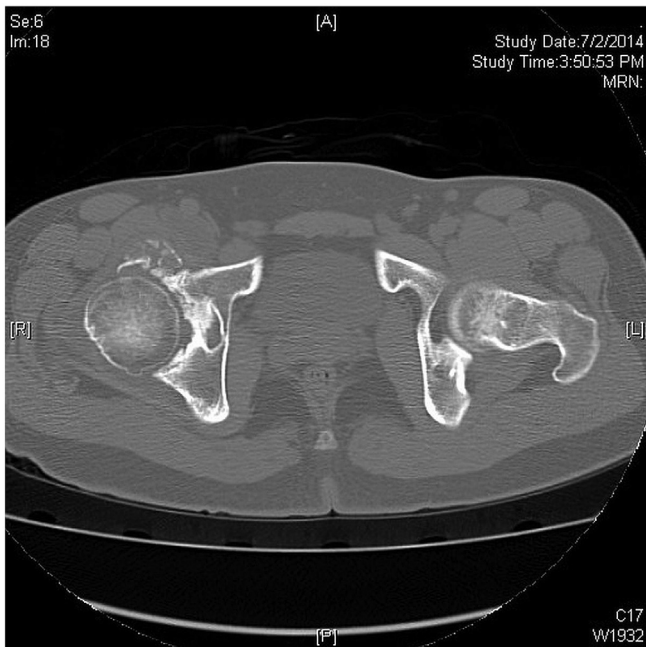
CT scan showing intra-acetabular osteochondroma with extension to medial aspect of femur.
